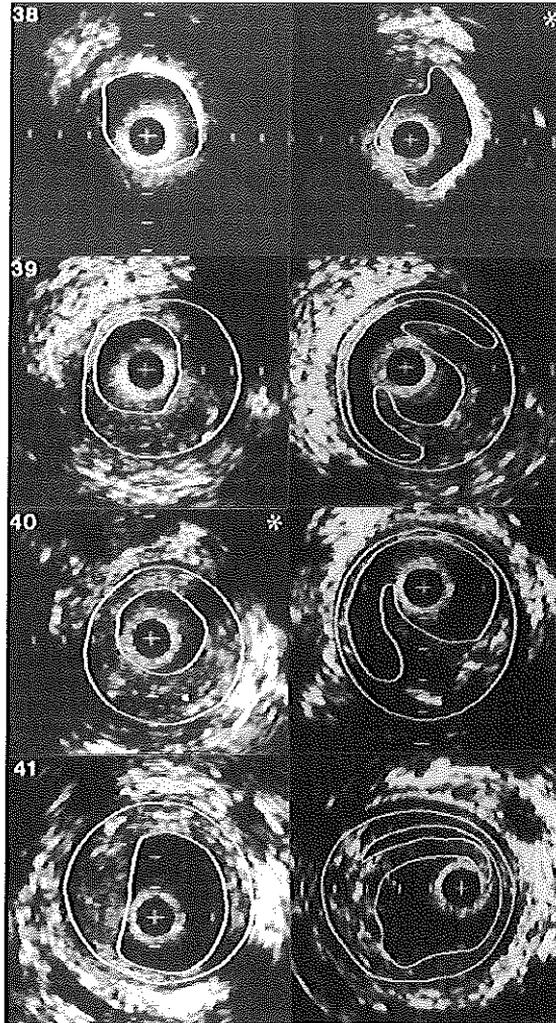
Corresponding intravascular ultrasound (IVUS) cross-sections obtained before (left) and after (right) balloon angioplasty (PTA) of the femoropopliteal artery. The IVUS cross-sections are contour traced off-line facilitating the recognition of lumen area (LA; inner contour) and media-bounded area (MBA; outer contour). At level 38 the presence of a hard lesion prevented measurement of the MBA. Distally the lesion was classified as soft. After PTA, dissections were seen at level 39 to 41. * = cross-section with the smallest LA; + = catheter; calibration = 1 mm.
